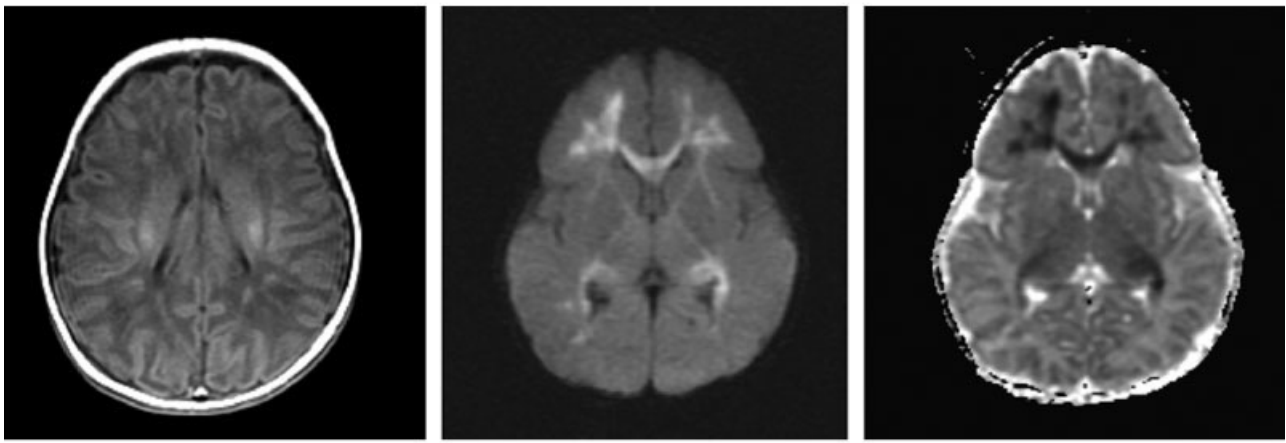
Magnetic resonance images (MRIs) obtained 1 day after the onset of human parechovirus (HPeV) infection (Patient 9). Note multifocal punctate areas of high T1 signal (left) and in deep white matter (WM). Diffusion-weighted imaging (middle) and apparent diffusion coefficient (ADC) map (right) demonstrate extensive areas of restricted diffusion in the periventricular WM, deep WM, corpus callosum, internal capsule, posterior thalami, optic radiations, and cerebral peduncles.
